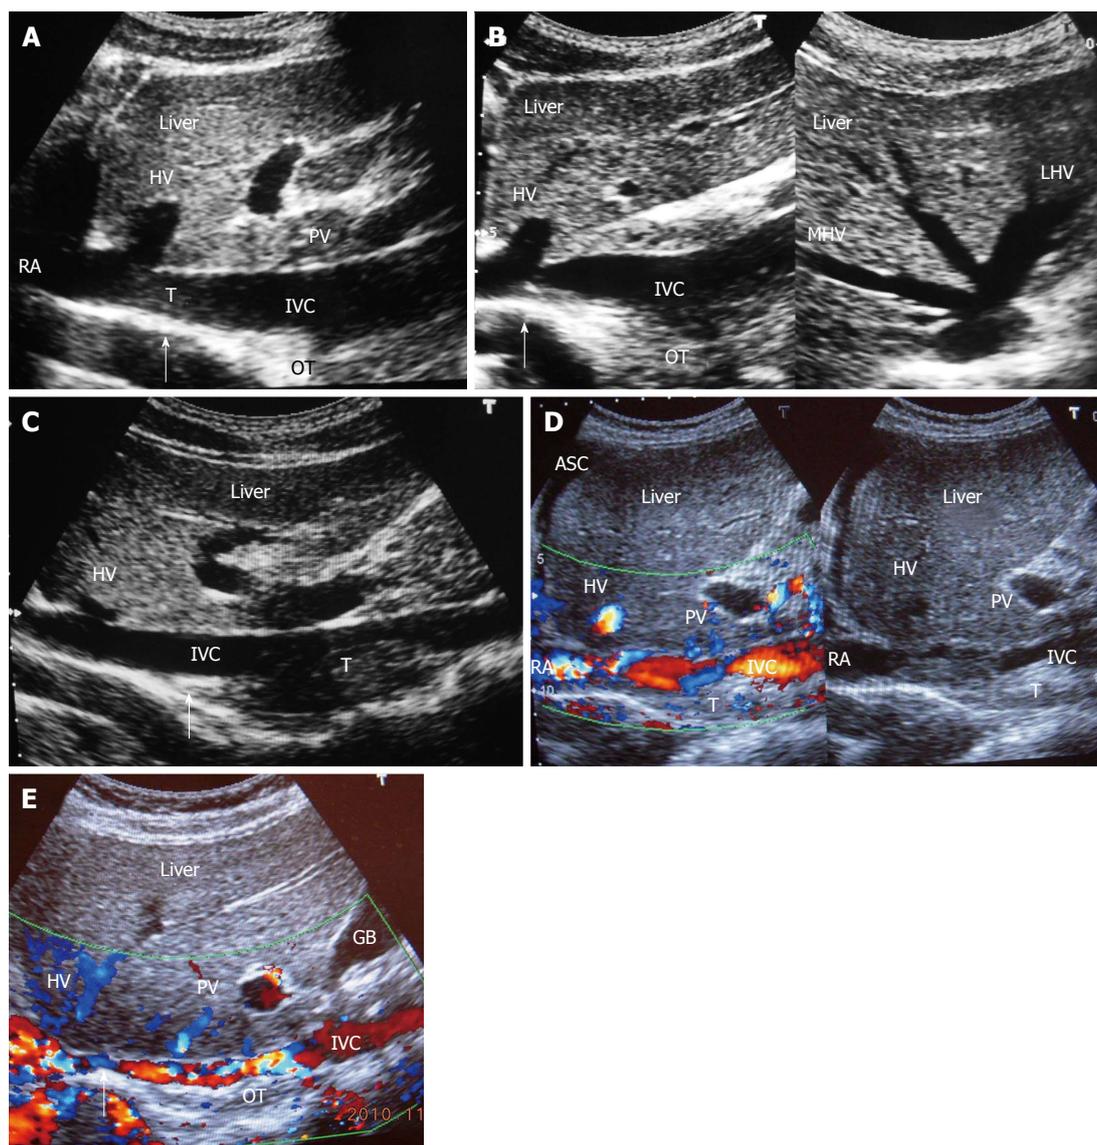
Ultrasonography showing thrombi of different ages in inferior vena cava due to recurrent acute exacerbations. A: Ultrasonography showing mild stenosis of inferior vena cava (IVC) with thick echoic posterior wall at cavo-atrial junction. It shows recent thrombus (T) and old organized thrombus (OT) deposited during recurrent acute exacerbation (AE); B: Ultrasonography showing stenosis of IVC at cavo-atrial junction, with OT along posterior wall just distal to it. Middle hepatic vein (MHV) and left hepatic vein (LHV) hepatic veins are patent; C: Ultrasonography showing mild stenosis of IVC at cavo-atrial junction and thrombus of different ages along the posterior wall of the IVC; D: Ultrasonography showing features of HV outflow obstruction-hepatomegaly and ascites (ASC) in a patient with IVC stenosis near cavo-atrial junction and IVC filled with recent and old organized T; E: Ultrasonographic evidence of recurrent AE; Color Doppler ultrasonography showing layers of linear old OT along posterior wall of the hepatic portion of the IVC narrowing its lumen. Arrow indicates to the site of initial lesion in IVC. USG also shows segmental stenosis of HV. PV: Portal vein; HV: Hepatic vein; RA: Right atrium; GB: Gall bladder.
